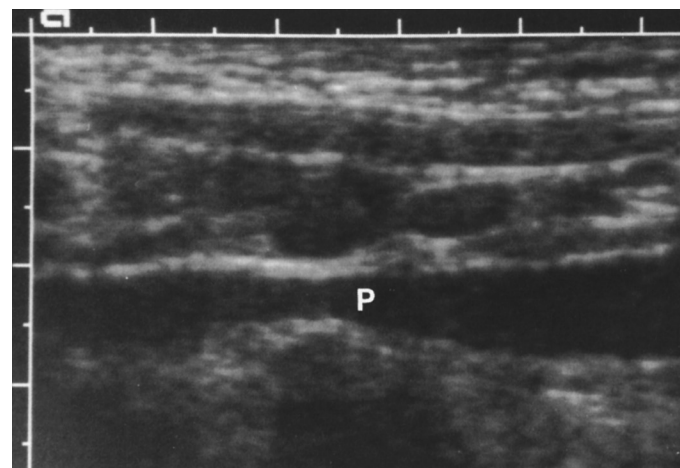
This longitudinal scan of the right lower quadrant shows lymph nodes arranged in a line along the psoas muscle (P). These are nodes enlarged from mesenteric adenitis. The patient did not have appendicitis. (From Teele R, Share J. Appendicitis and other causes of intraabdominal inflammation. In: *Ultrasonography of Infants and Children*. Philadelphia: WB Saunders; 1991.)
